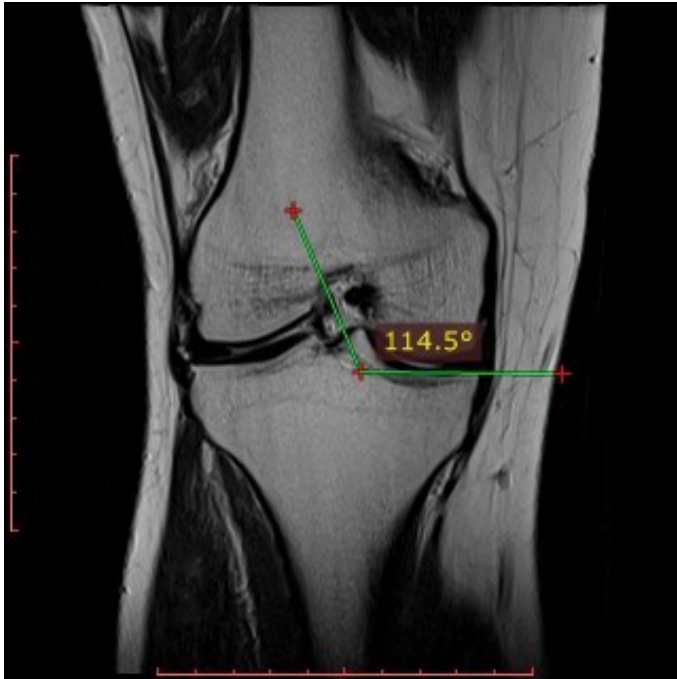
Coronal MRI showing the measurement of the PCL angle.
